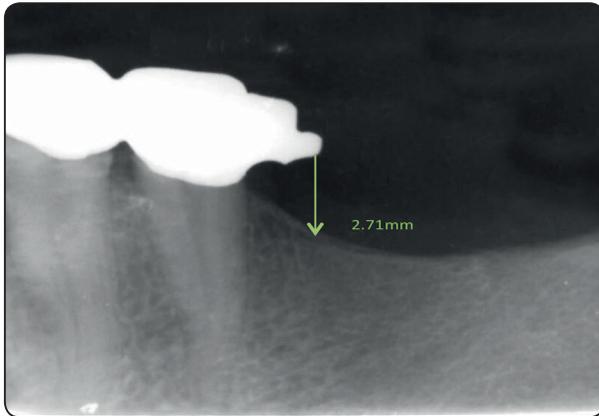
Radiographic assessment using Digora software
